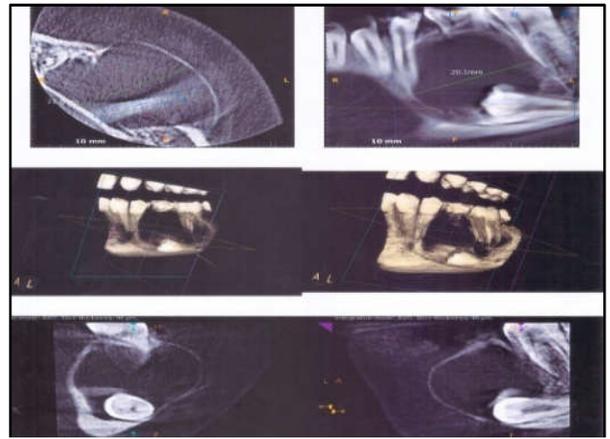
CBCT of the patient
